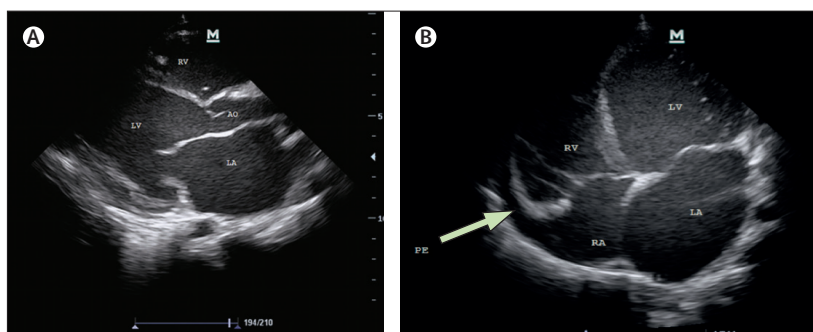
Echocardiogram of a girl aged 12 years with HIV
